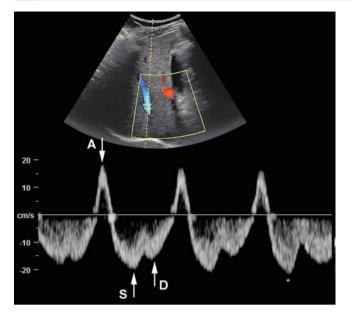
Exaggerated hepatic venous A-waves. Color and spectral Doppler of hepatic vein showing large A-wave (*arrow*, A) of retrograde flow during atrial contraction, with normal appearing S- (*arrow*, S) and D (*arrow*, D) waves
